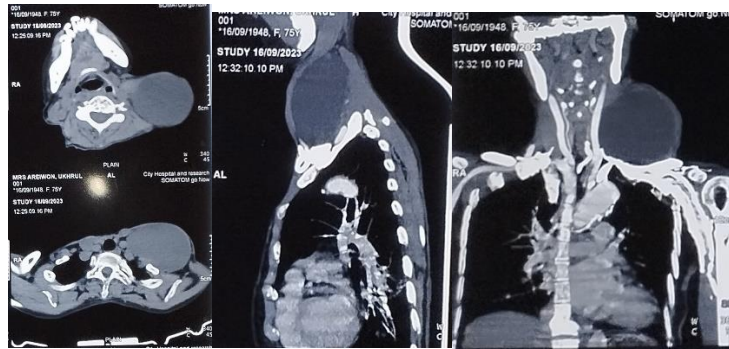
CT scan of left cervical lymphocele
